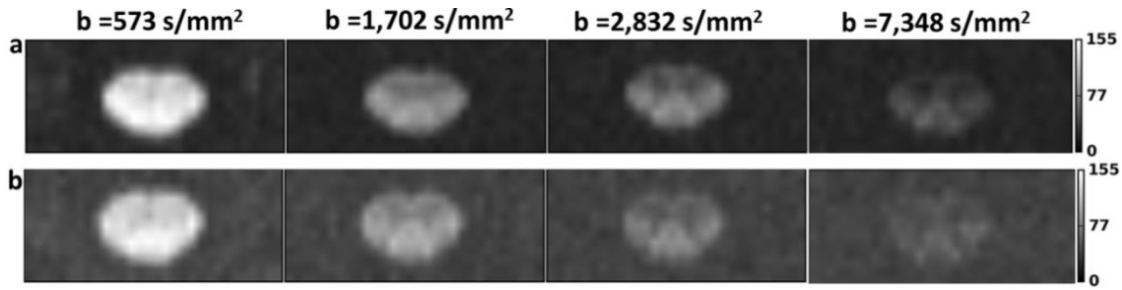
Ultrahigh- b radial DWI: Images for different b -values using (a) the CSC coil and (b) the manufacturer's coil. The same scale is used in each row.
